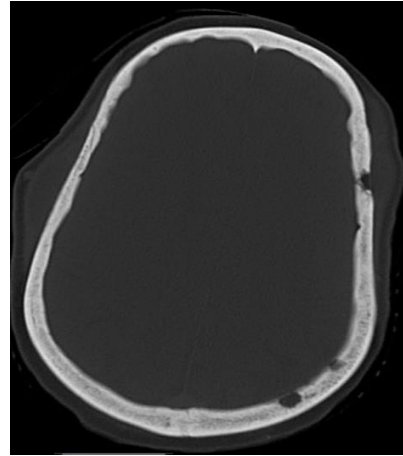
CT head showed multiple lytic lesions.
